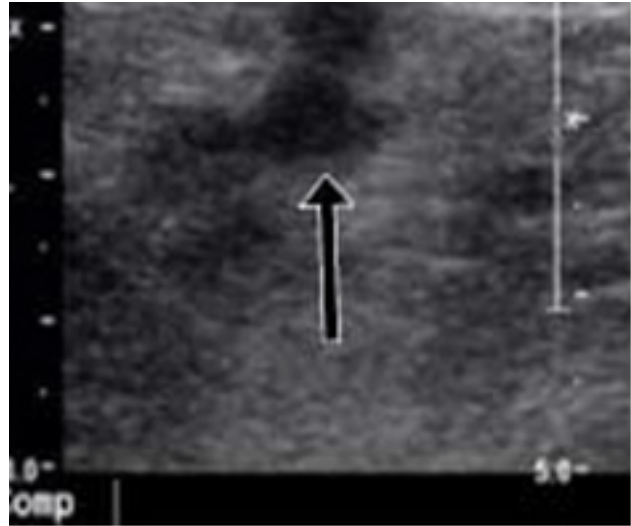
Doppler ultrasound of left lower limb showing deep venous thrombosis (↑)
